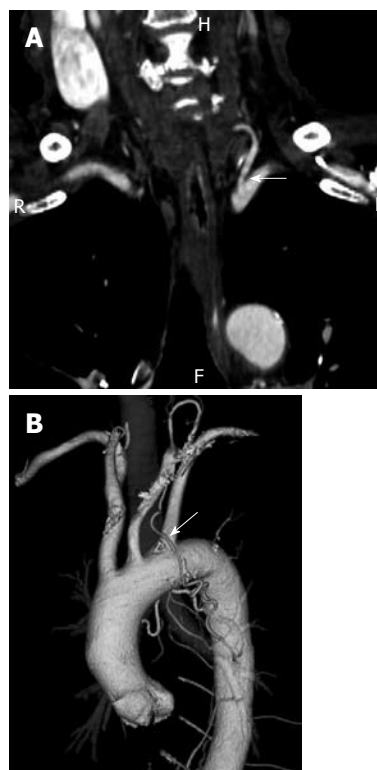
Left bronchial artery arising from the left subclavian artery is indicated by arrows on a reformatted coronal computed tomography image with mediastinal soft-tissue lung window settings (A) and on a thin-section maximum intensity projection image of a three-dimensional volumetric reformatted image (B).
